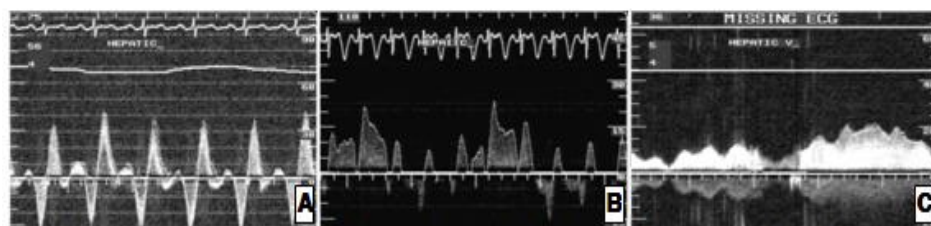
Intravascular Doppler spectrals at HV in 3 groups (A;APC group, B;LTF group, C;ECF group)
